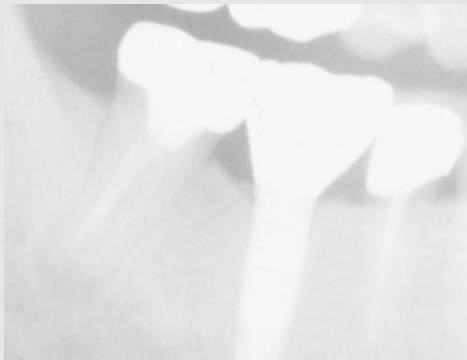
Doubtful case: pre-op periapical view.
